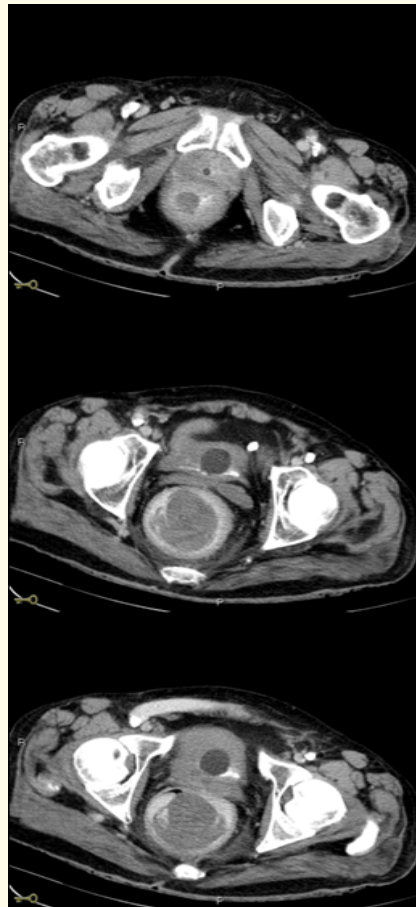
CT angiography, showing diffuse contrast extravasation in the last 20 cm of the digestive tract.
